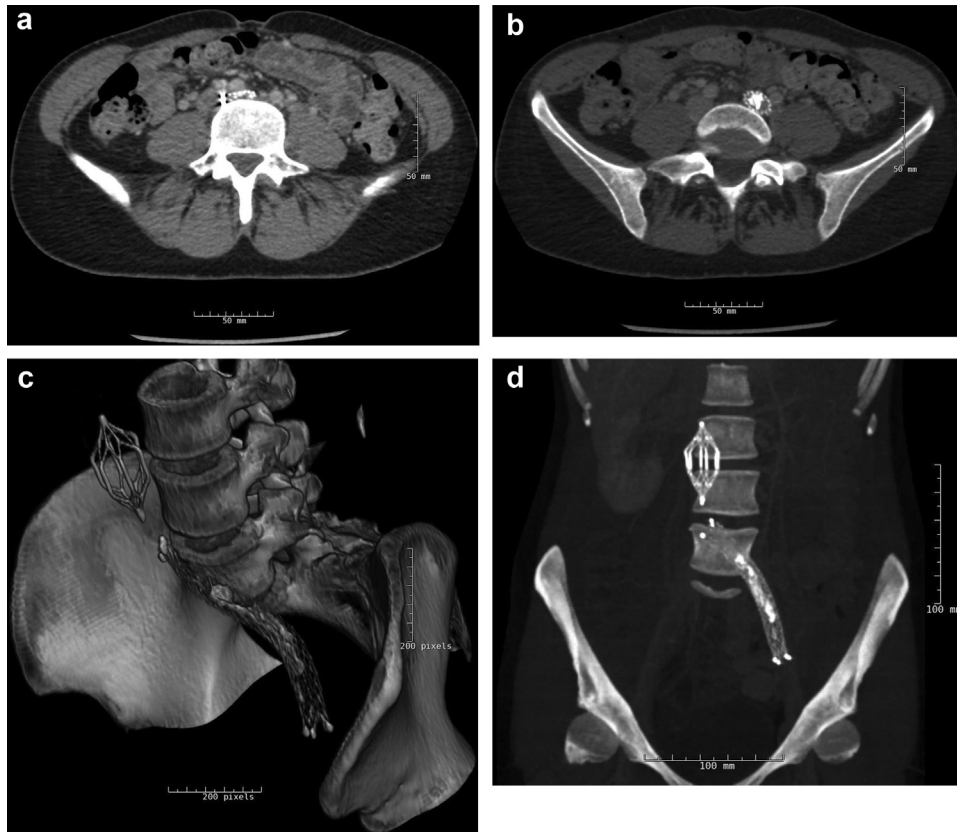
Computed tomography scans showing compression of the stent at the May-Thurner point (a) and high-density (calcified) material inside the stent distal to the compression (b). Three-dimensional reconstructions of these scans show the entire stent, including the compressed outflow and the calcified material within it as well as the vena cava filter (c and d).
